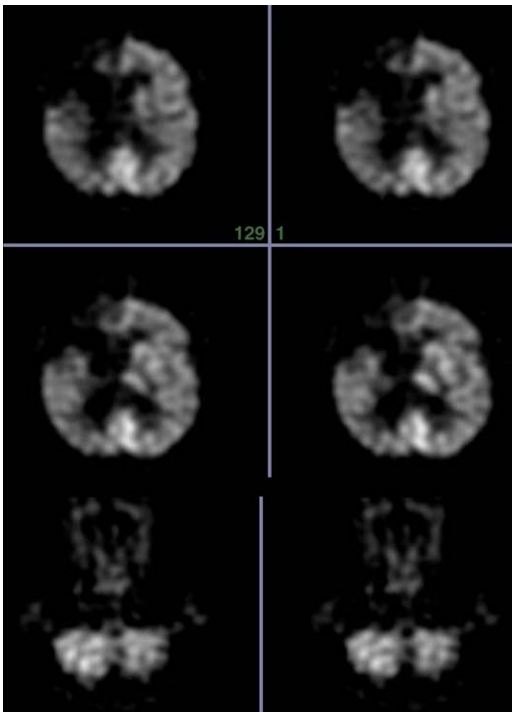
FDG-PET scan of a patient after embolic stroke in the distribution of the right anterior cerebral artery. There is severely decreased metabolism in the right frontal lobe extending to the midline. There is also crossed cerebellar diaschisis with decreased metabolism in the left cerebellum.
